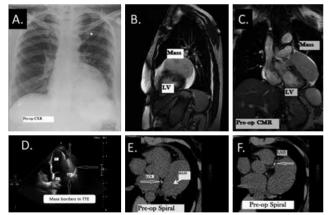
Different preoperative cardiac imaging modalities; (a) Chest X-ray; (b) Sagittal view of cardiac magnetic resonance; (c) Coronal view of magnetic resonance; (d) Echocardiographic four-chamber view; (e) Anatomic relationship between the mass and left circumflex artery; (f) Anatomic relationship between the mass and left anterior descending artery.
